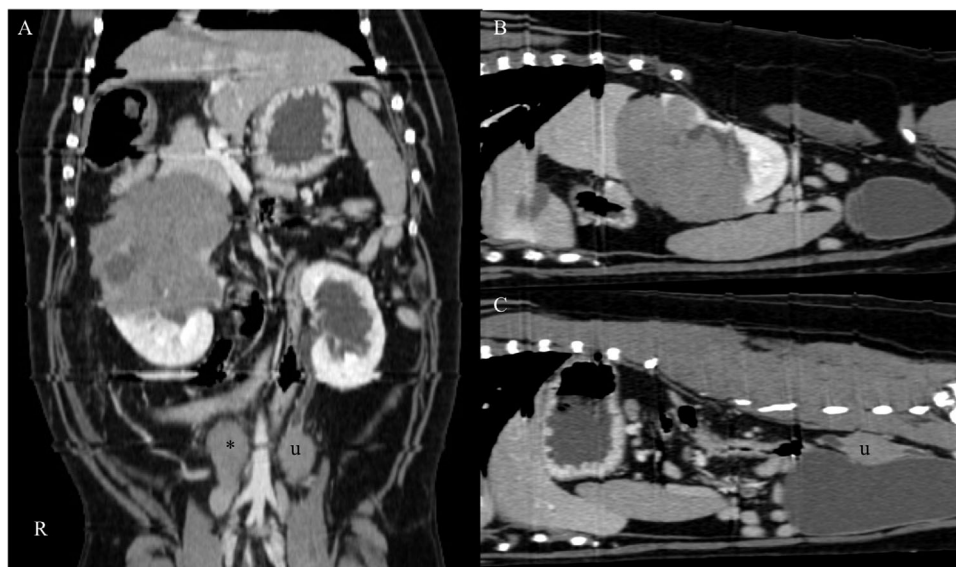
Computed tomographic images after contrast administration. In the dorsal reconstruction view, an enlarged mass on the cranial pole of the right kidney, severe hydronephrosis of the left kidney, enlargement of the right medial iliac lymph node (*) and the ureteral mass (u) of the left ureter was seen (A). Sagittal reconstruction view of the right side of the abdomen showing the enlarged mass of the right kidney (B). Sagittal reconstruction view towards the left side of the abdomen where the ureteral mass (u) was nicely depicted dorsal to the urinary bladder (C)
